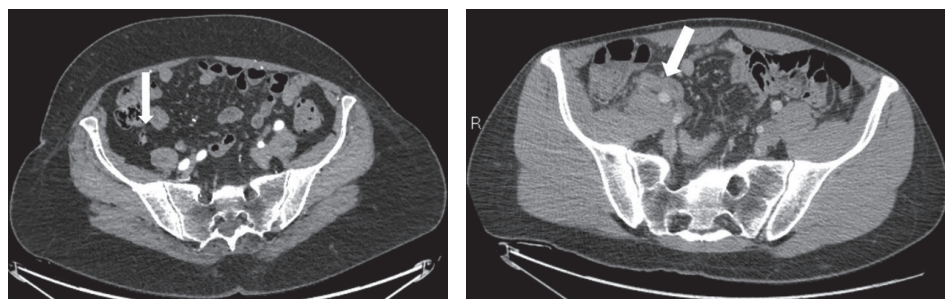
On the left, CT image of normal appendix and on the right, an uncomplicated acute appendicitis with appendiceal wall thickening and edema.
